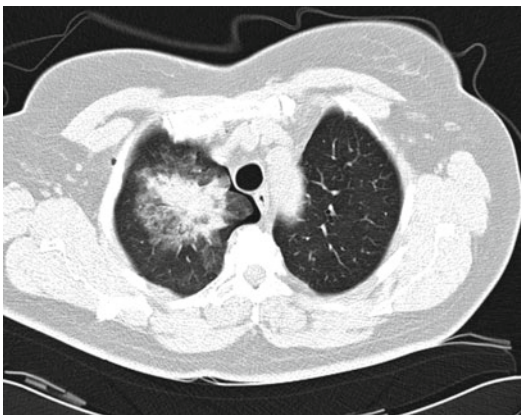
The post-interventionally planned CT scan shows the coagulated target lesion which is surrounded by an area of ground-glass opacity. Note the small medial pneumothorax
